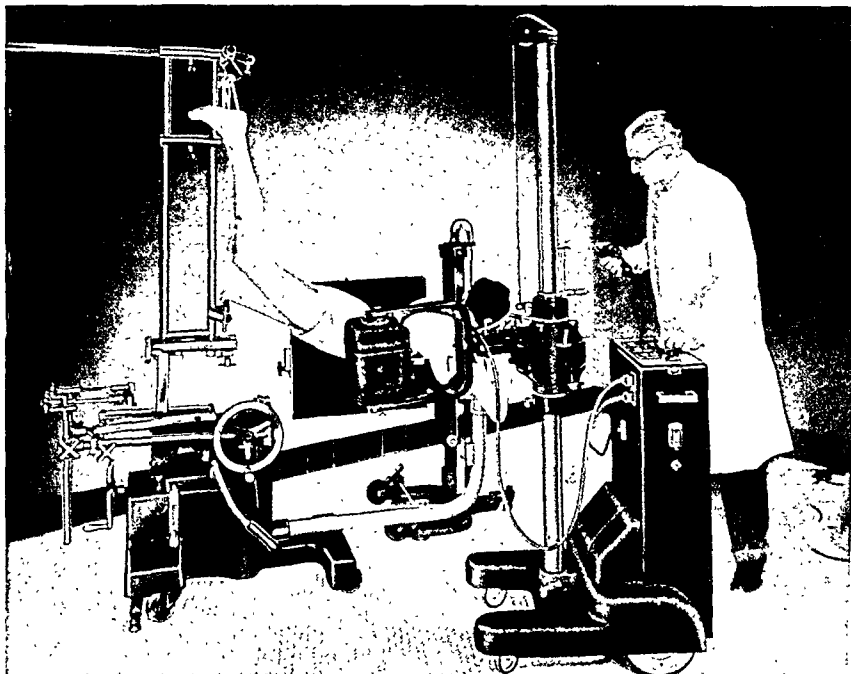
Lateral radiography with mobile Potter-Bucky diaphragm. For antero-posterior radiograph Bucky diaphragm may be placed at desired angle immediately under patient.
